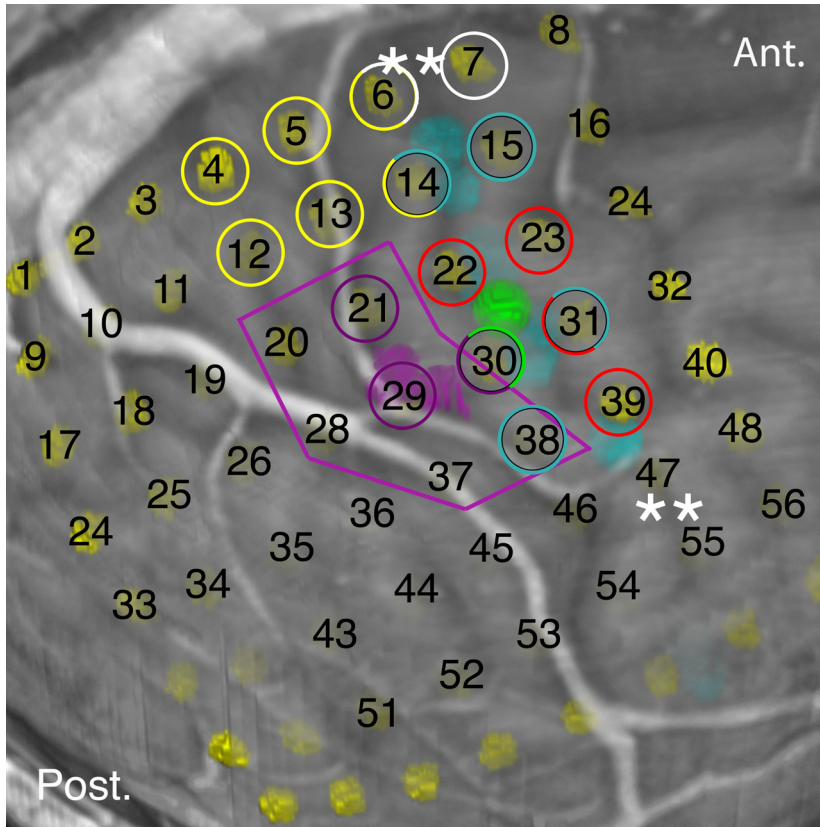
A 3-D MRI reconstruction of a patient in epilepsy surgery planning. The results from all the techniques used preoperatively and intraoperatively are presented. ECS grid electrodes are shown in yellow and are numbered. MEG ictal source area is depicted by purple and SEF ECD-sources of left median nerve responses by green colour. Stimulations of grid electrodes marked with purple circle elicited habitual and those marked with red circles non-habitual seizures. nTMS activations of hand and arm muscles are depicted by turquoise. The resected area is delineated by a purple line. The double asterisks () indicate the location of the central sulcus. Ant. stands for anterior and Post. for posterior view.
